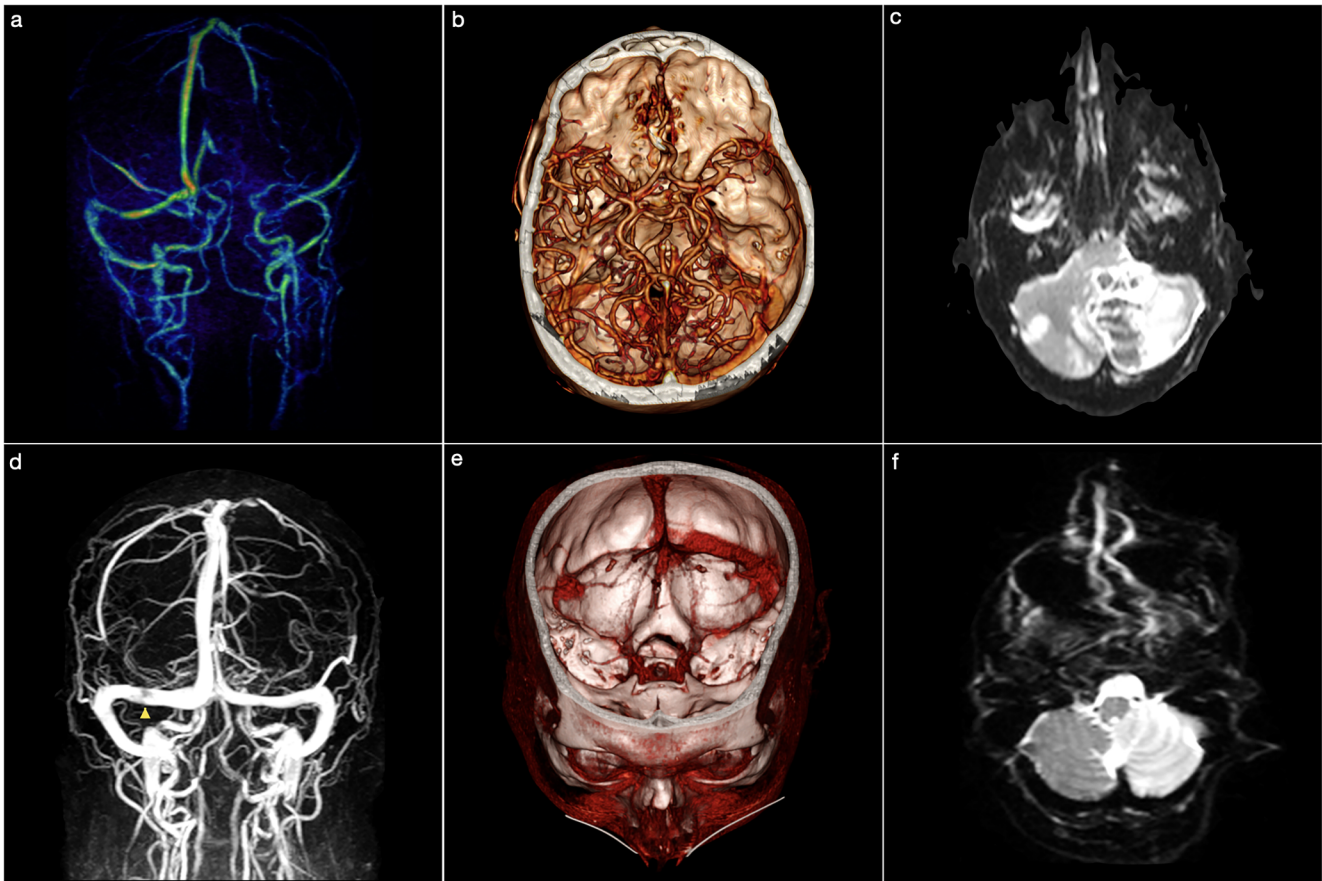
(a) 3D Time-of-Flight MRI showing a right thrombosis of the transverse and sigmoid sinus, and jugular bulb. (b) 3D CT angiography revealing a right middle cerebral artery occlusion. (c) Axial diffusion-weighted MRI documenting a left cerebellar hemispheric ischemia. (d) 3D Time-of-Flight MRI showing a partial occlusion of the right transverse sinus (yellow arrowhead). (e) 3D CT angiography acquired in venous phase demonstrating a thrombosis of the right transverse sinus. (f) Axial diffusion-weighted MRI showing an ischemia of the right cerebellar hemisphere. (For interpretation of the references to colour in this figure legend, the reader is referred to the web version of this article.)
